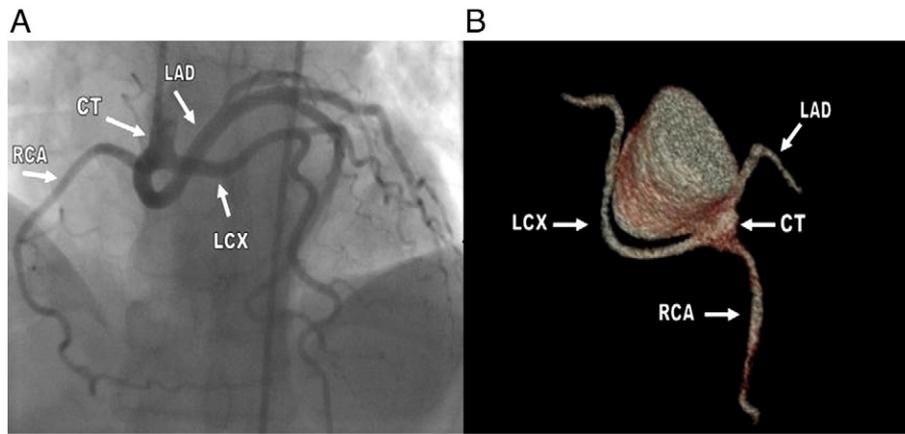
A: Catheter coronary angiography image shows trifurcation of common trunk (CT: common trunk) B: 3D image of MSCT coronary angiography demonstrates trifurcation of common trunk (MSCT: Multislice computed tomography, CT: common trunk).
